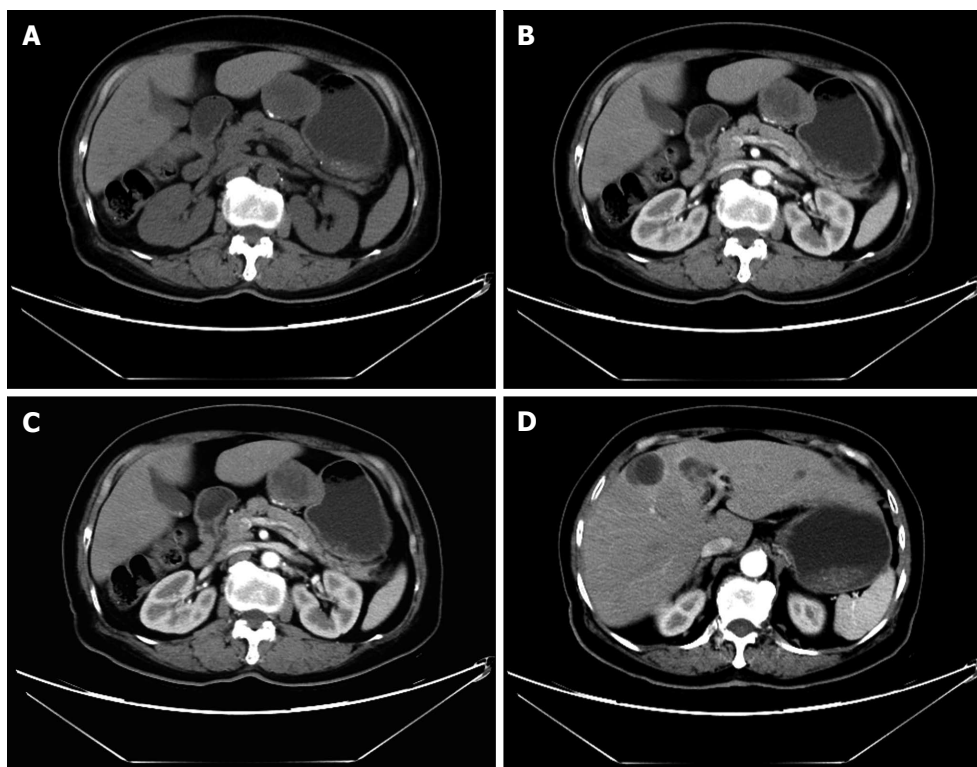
A 76-year-old female with gastrointestinal stromal tumors. Axial plain (A) shows an round, exophytic soft tissue mass, appearing as a dominant mass extrinsic to the wall of the stomach, contrast-enhanced computed tomography arterial (B) and venous phase (C) scan shows slightly enhancing, occasionally with coarse calcification. Liver metastases were shown (D).
